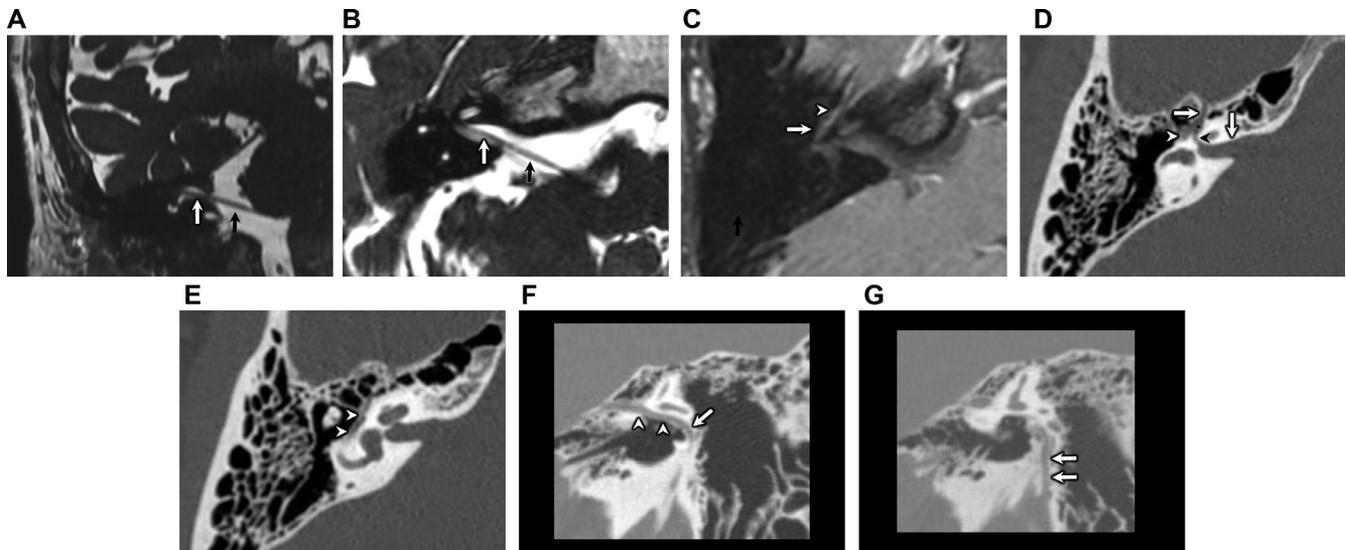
Normal facial nerve anatomy. Coronal (A) and axial (B) fast imaging employing steady-state acquisition images demonstrate the normal thickness and course of the cisternal (black arrows) and canalicular (white arrows) segments of the right facial nerve traversing the cerebellopontine angle. (C) Axial T1-weighted postcontrast fat-saturated image. Normal smooth enhancement of the right geniculate ganglion (white arrowhead) and tympanic segment (white arrow) of the facial nerve is typically seen and should not be mistaken as abnormal. The cisternal and canalicular segments of the facial nerve do not normally enhance. (D) and (E) Axial temporal CT without contrast. (D) The normal internal auditory canal is funnel shaped (vertical white arrow). The labyrinthine segment (black arrowhead) takes a sharp anterior turn toward the geniculate fossa (black asterisk) where the greater superficial petrosal nerve exits the facial hiatus (horizontal white arrow) and extends anteriorly toward the foramen lacerum. The facial nerve then makes a sharp turn posteriorly to form the tympanic segment (white arrowhead) that courses along the medial margin of the middle ear cavity. (E) The tympanic segment (white arrowheads) of the facial nerve courses along the medial margin of the middle ear cavity. (F) and (G) Sagittal oblique temporal bone CT reformat. (F) The tympanic segment (white arrowheads) of the facial nerve is seen coursing posteriorly, just inferior to the lateral semicircular canal along the along the medial margin of the middle ear cavity. At the posterior genu (white arrow), the facial nerve then turns inferiorly. (G) The vertical or mastoid segment (white arrows) then courses caudally and exits the stylomastoid foramen.
